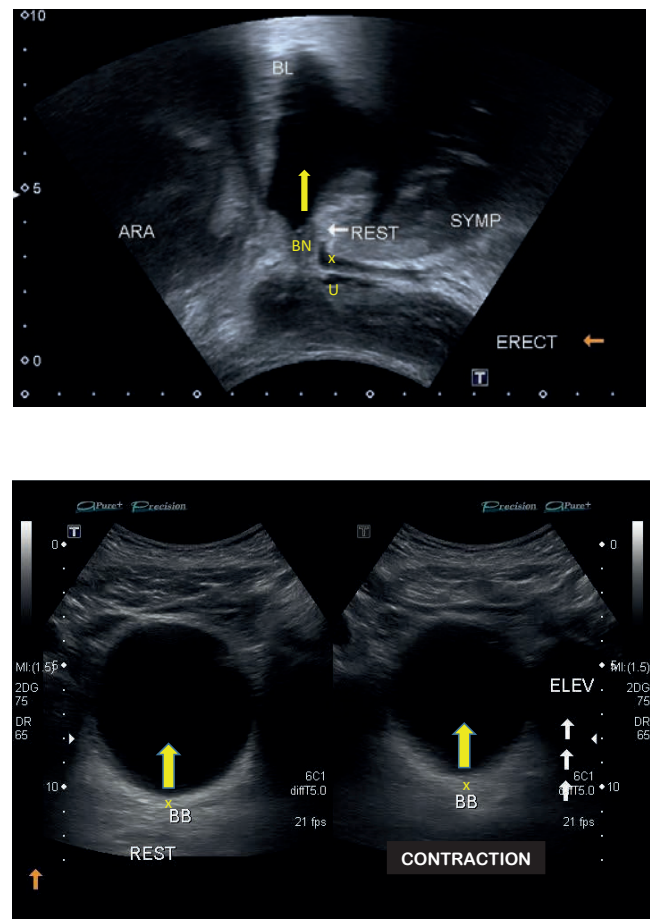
Upper panel: Transperineal real time ultrasound image (RTUS) image used to assess pelvic floor muscular (PFM) function utilising screen calipers to determine correct PFM action during the rapid response test (RRT) and sustained endurance test (SET). Movement should be in a cranial direction as indicated by the arrow. BL = bladder, BN = bladder neck seen in relation to SYMP = symphysis pubis, U = urethra, ARA = anorectal angle and bladder. Lower panel: Transabdominal (TrA) RTUS images used to assess PFM action during the RRT and SET (left image = at rest; right image = whilst contracting). BB= base of bladder and arrows indicate direction of pelvic floor muscles.
